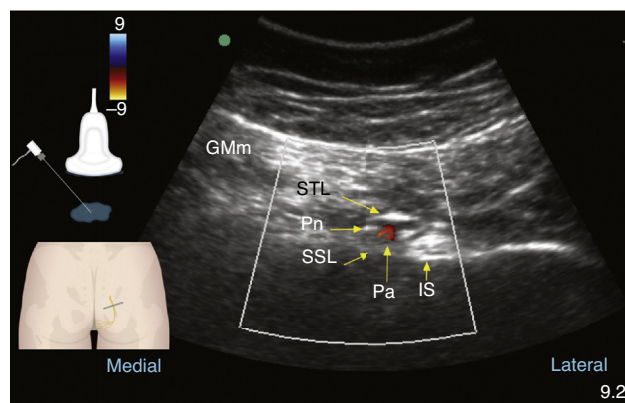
Colour Doppler ultrasound at the gluteal level: pudendal nerve (Pn), gluteus maximus muscle (GMm), deep to the sacrotuberous ligament (STL) and superficial to the sacrospinous ligament (SSL); the internal pudendal artery (Pa) and the ischial spine are found lateral to these structures. Source: Author.
